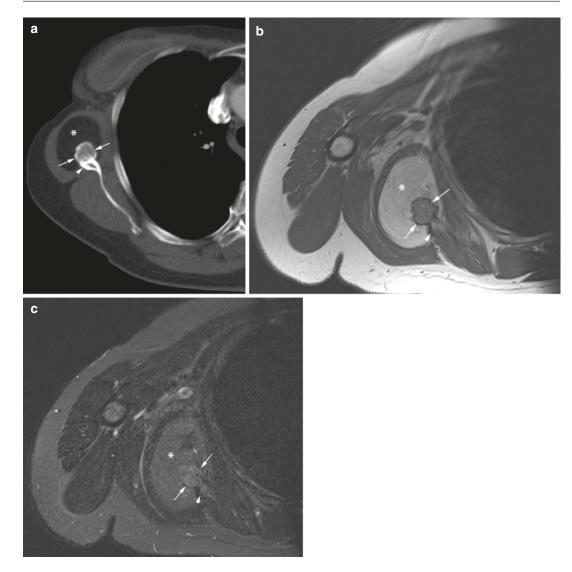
(a–c) Parosteal lipoma of the right scapula in a 28-year-old woman. (a) CT of chest. (b) Axial SE T1-weighted MR image. (c) Axial fat-suppressed SE T2-weighted MR image. CT and MR images show a large
